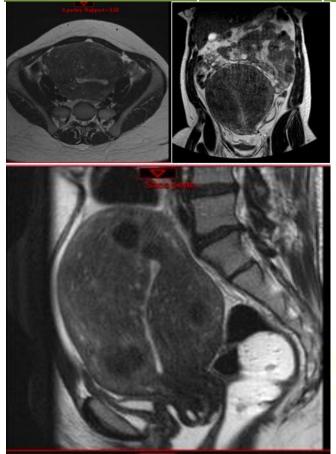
a b and c MRI axial, coronal and sagittal T2 sequence: adenomyosis characterized by diffuse thickening of the myometrium with nodular T2 hypersignals corresponding to crypts.
